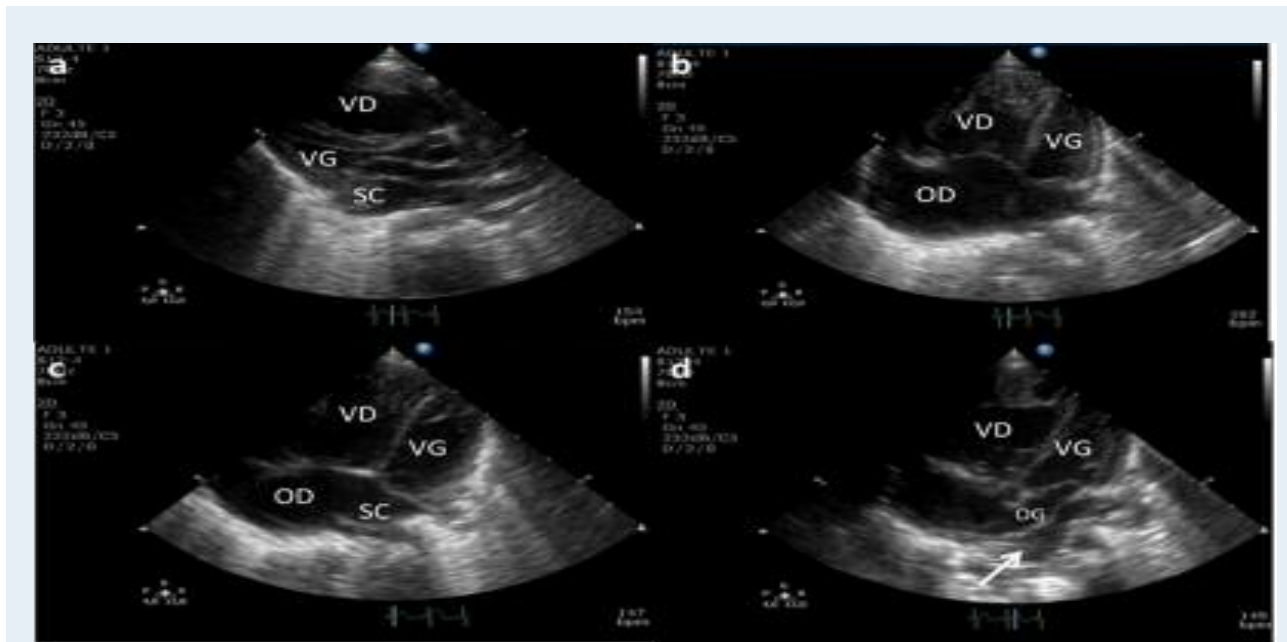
(a) coupe échographique parasternale grand axe montrant un VD dilaté et un sinus coronaire dilaté.(b)coupe apicale 4 cavités montrant une petite OG et une OD dilatée.(c) la coupe 4 cavités tronquées en post permet de dégager un sinus coronaire dilaté.(d)le collecteur se situe derrière l'OG et reçoit les 4 veines pulmonaires
